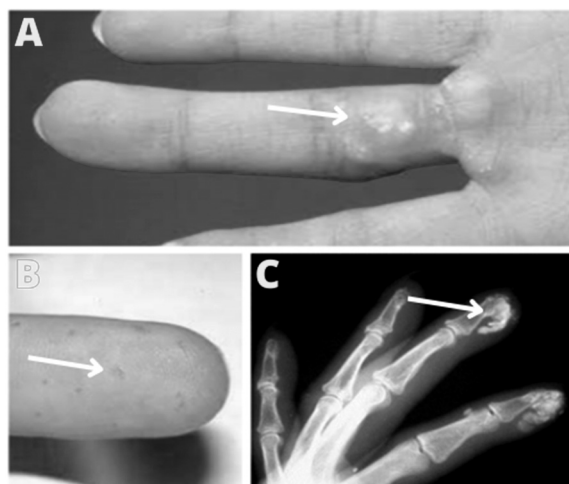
Calcinosis of the right hand (A); Telangiectasias of the left hand (B); Left hand X-ray shows calcification (C)
